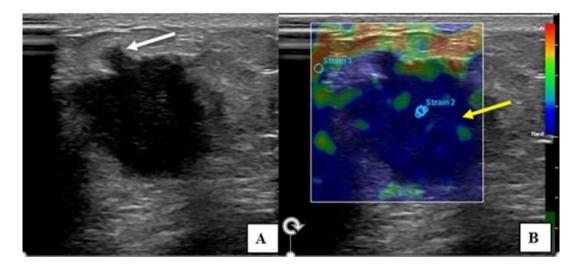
(A) Ultrasound grey scale image of a well-defined hypoechoic solid lesion with spiculated margins (thick white arrow) suggestive of BIRADS 5. (B) On elastography, the lesion (thick yellow arrow) showed uniform blue colour pattern suggestive of malignancy.
